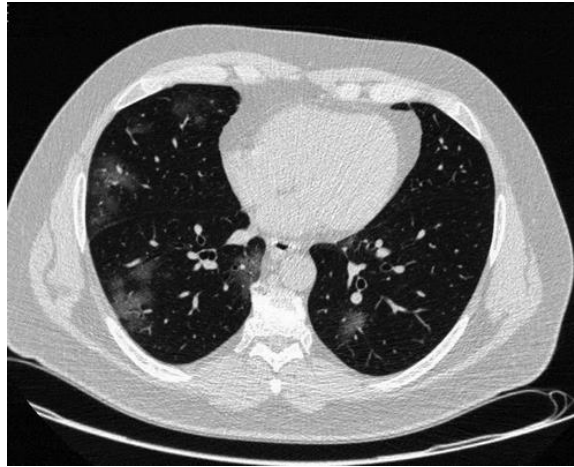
Axial CT image at presentation shows bilateral pleural-based ground glass opacities.
